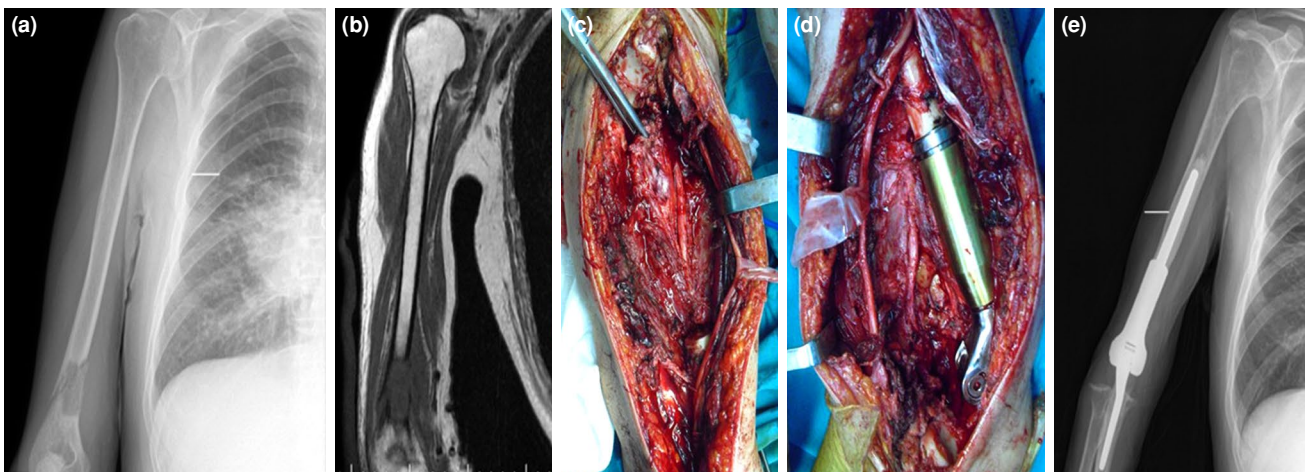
(a) Preoperative X-ray example of distal humerus pathological fracture (pulmonary adenocarcinoma metastasis), (b) preoperative magnetic resonance imaging coronal image, (c) intraoperative imaging before prosthesis, (d) intraoperative imaging before prosthesis, (e) postoperative humerus distal tumor resection arthroplasty.
